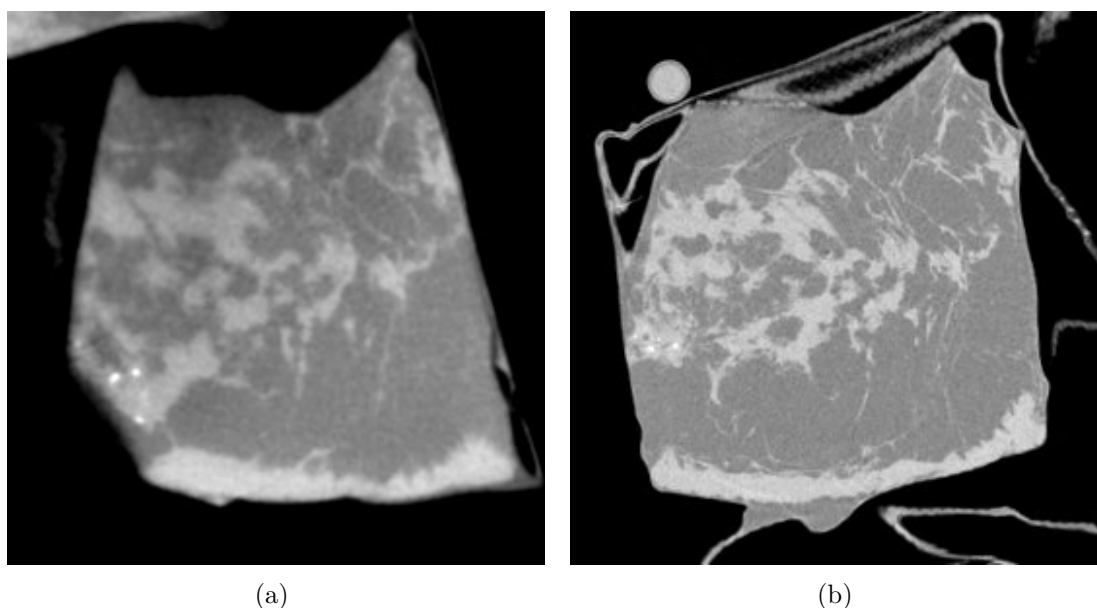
Sample P19009. Excised breast sample from a 62 years old woman, including an invasive ductal carcinoma with DCIS. a) image obtained with the Köning dedicated breast-CT system. b) image obtained with PB-CT technique
